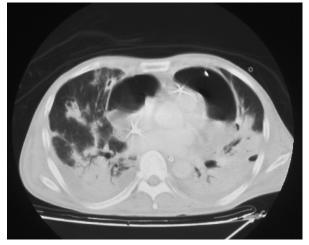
Chest radiograph shows a tube drain was introduced into the pericardial cavity.
